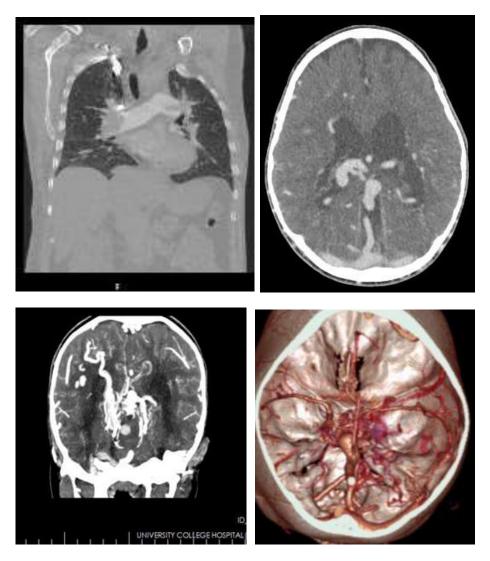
A- Coronal CT MPR showing hypodense filling defect in both right and left main bronchus in Pulmonary embolism, B, C and D- Axial image, coronal reformat and SSD image showing multiple dilated, tortuous arteries and early filling of the Dural sinuses- in Parietal lobe Arterio-venous malformation.
